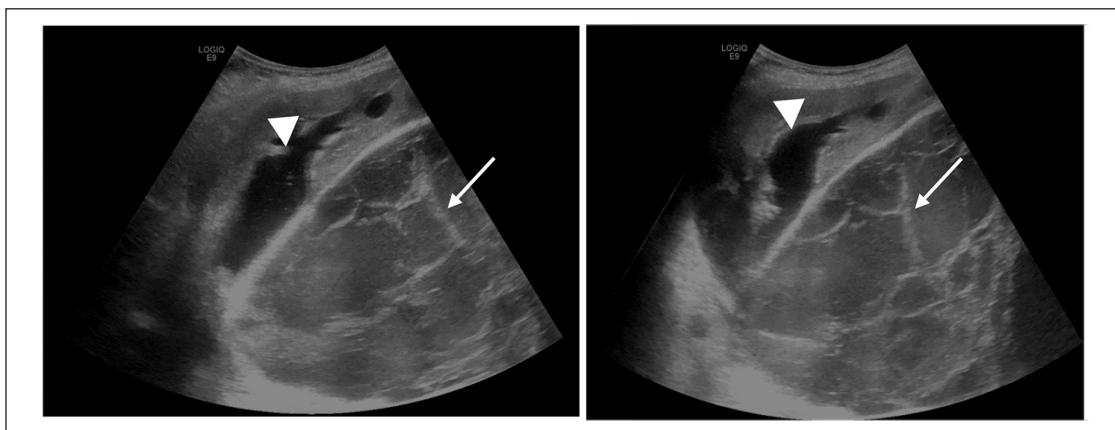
Ultrasound showing a thin-walled anechoic cyst containing multiple septa (arrow), displacing the kidney forward. Note the pyelo-calycal dilation (arrowhead).
